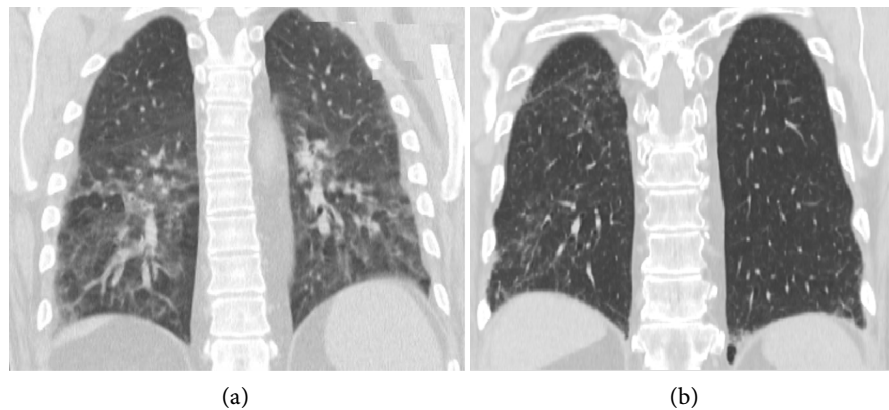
Coronal CT view showing significant bilateral, mosaic, ground glass opacities in the lower lung zones prior to Rituximab therapy (a) and improvement with just residual fine reticulation on the right posterior segments after therapy (b).
